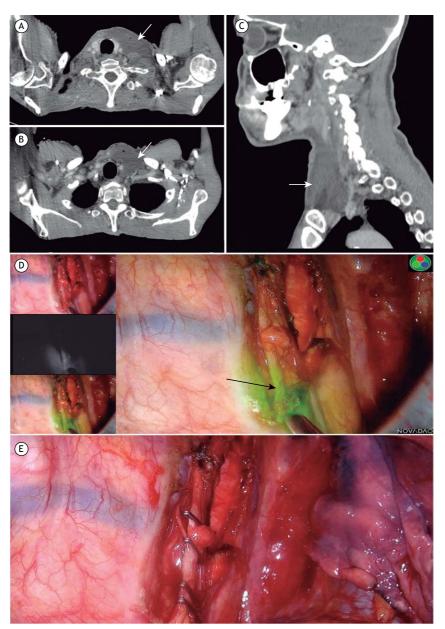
In A and B, CT scan of the neck showing a large fluid collection (arrow). In C, sagittal CT reconstruction. In D, intraoperative view of the thoracic duct dissected after injection of indocyanine green (arrow). In E, thoracic duct ligation with metal clips.
